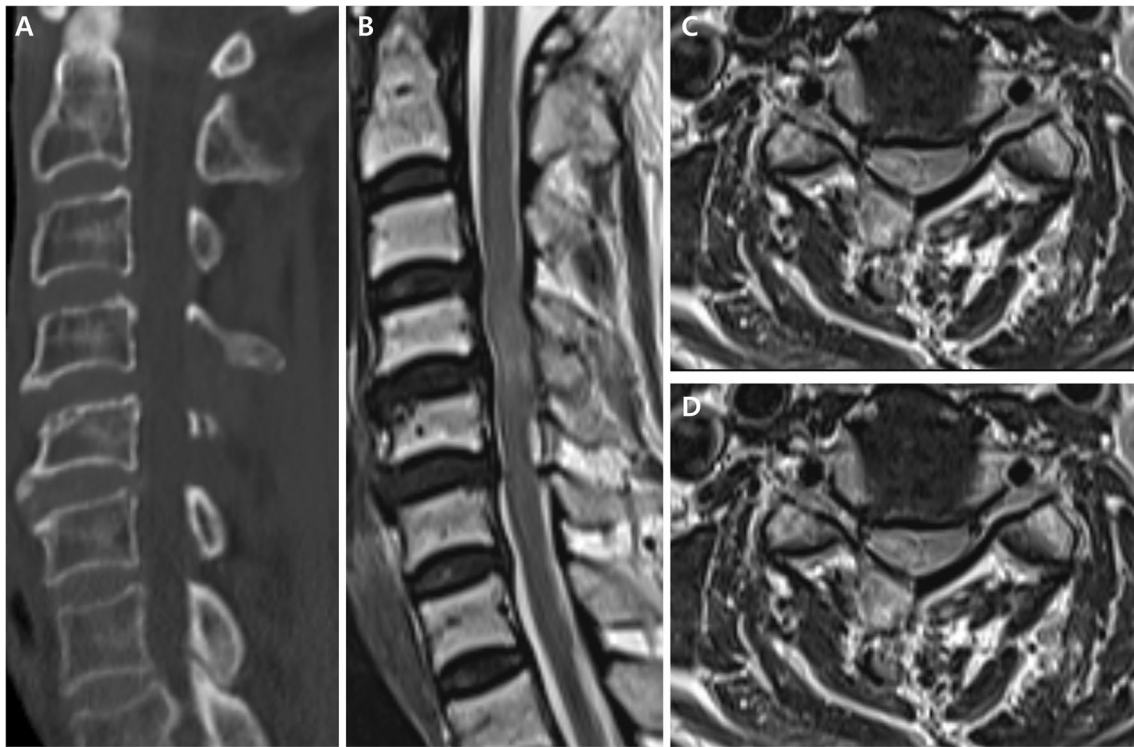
Post-operative images of Case 1. A: Sagittal plane of CT scan, confirming complete removal of the mass. B: Sagittal plane of MRI scan. C: Axial plane of MRI scan at C4-5 level. D: Axial plane of MRI scan at C5-6 level, indicating sufficient cord decompression after surgery
